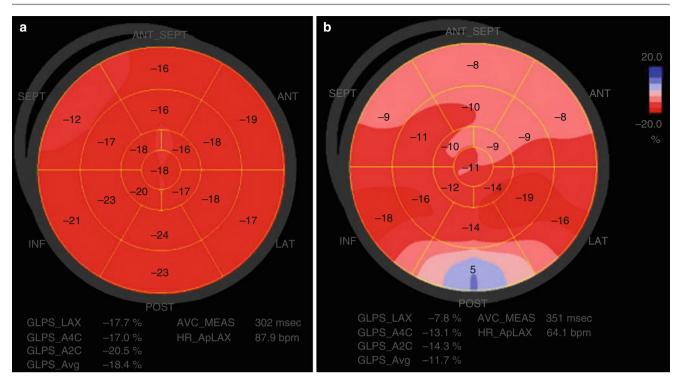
Speckle-tracking echocardiography in the patient prior to and after tyrosine kinase inhibitor therapy. (a) Speckle tracking prior to chemotherapy demonstrated normal global longitudinal peak strain
